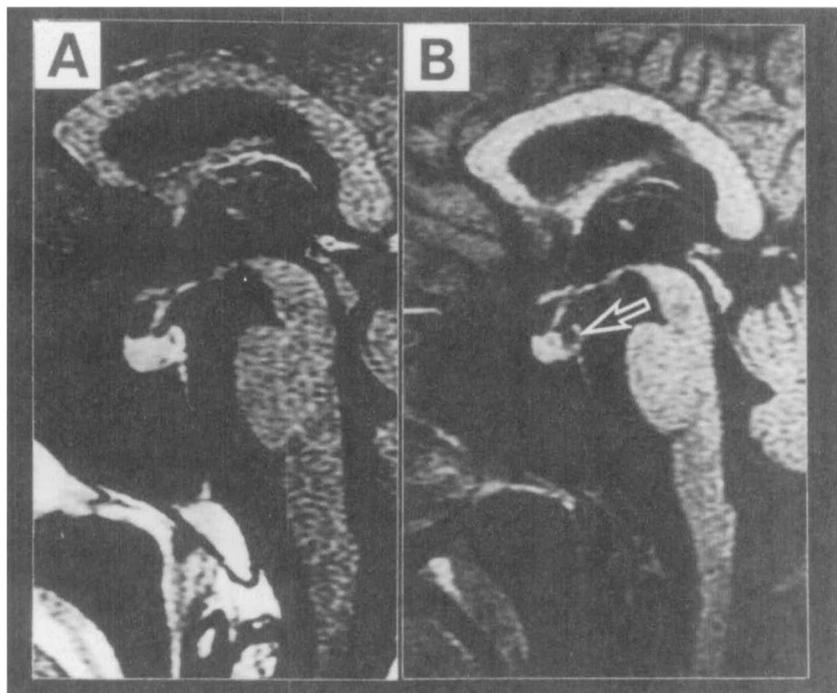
Cranial MRI findings. In 1992, the patient had no detectable lesion in the pituitary region (A). In December 1993, MRI exhibited a low-intensity pituitary mass (B, see arrow).
